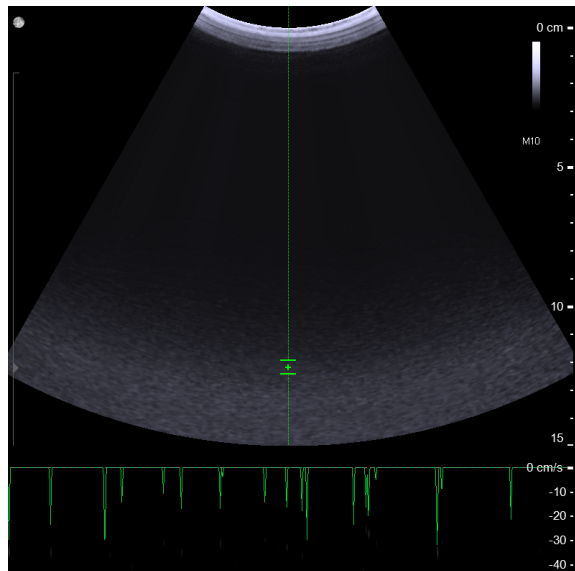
The Doppler indicator (line and gate) superimposed on a 2D image.
